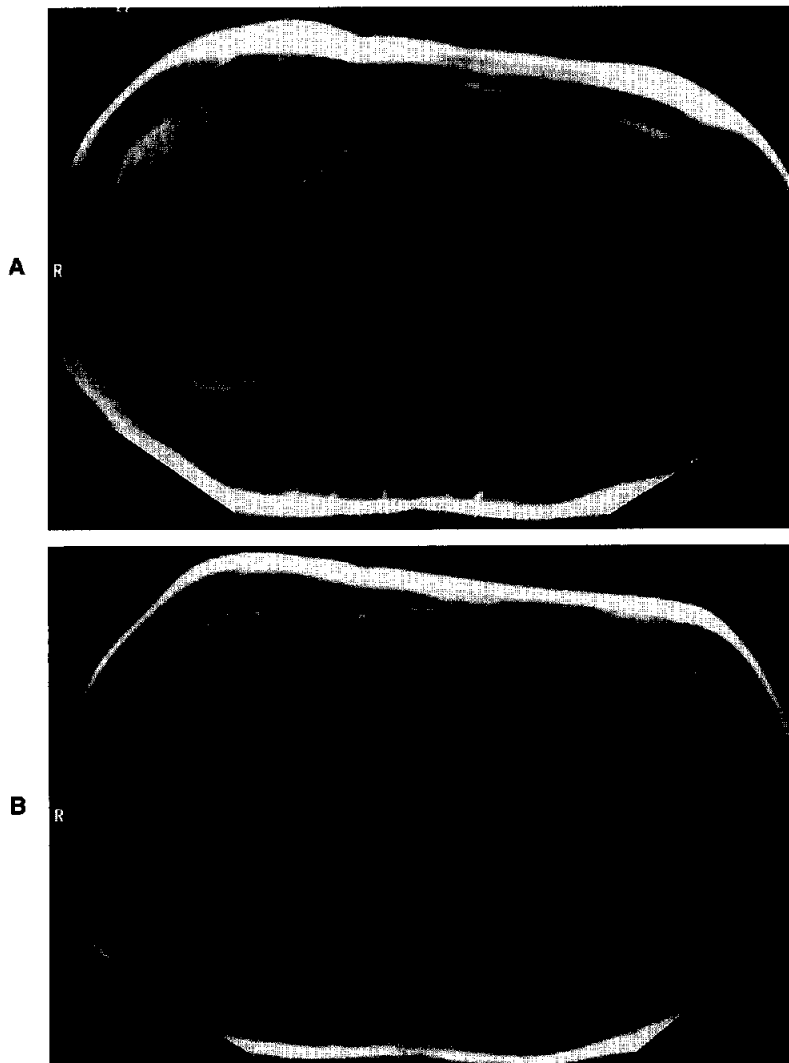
Adenocarcinoma of the head of the pancreas resected at surgery. A, Postcontrast gradient echo T1-weighted image (repetition time/echo time/flip angle = 183 msec/4.1 msec/90 degrees) shows a mass confined to the head of the pancreas (arrow). The mass is hypointense compared to the higher signal intensity of the adjacent parenchyma. B, This image was obtained at a more superior level and shows dilatation of both the pancreatic duct (arrows) and the common bile duct (arrowhead).
